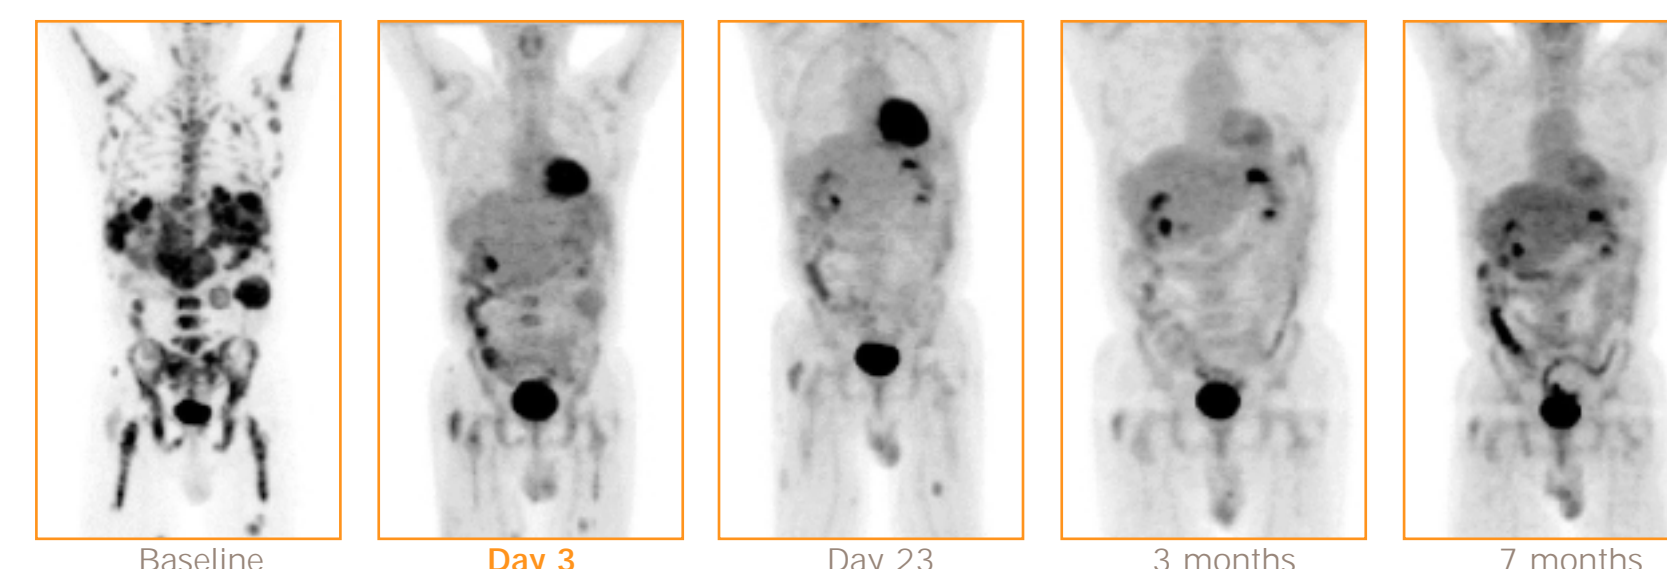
FDG-PET studies in a patient with extensive, highly FDG-avid abdominal, hepatic, bone marrow, and soft tissue involvement at baseline. Follow-up studies show evidence of response as early as 3 days following the initiation of therapy, and continuing response over time with no evidence of FDG-avid disease on the 7-month follow-up scan.
